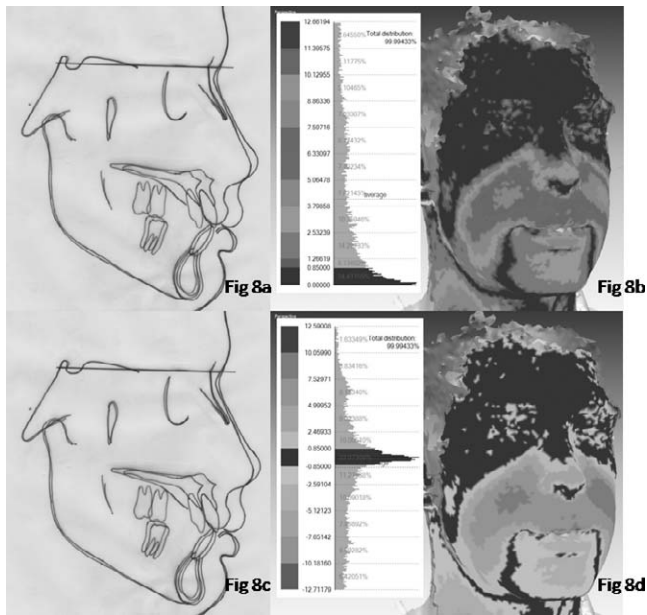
Subject W a) and c) Changes on the lateral cephalometric radiograph showed soft tissue changes. b) and d) The 3D superimposition revealed how the same landmarks moved forward.
